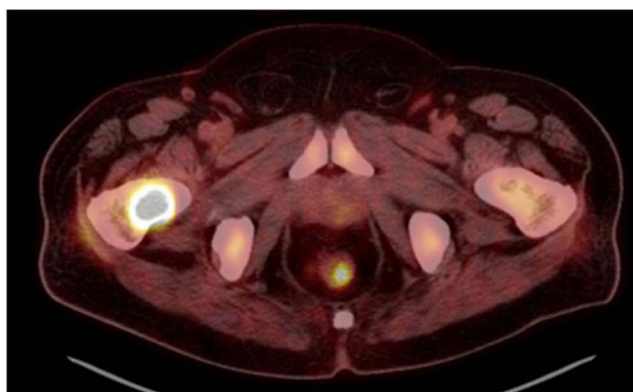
PET-CT scan showing radiotracer uptake of bone metastasis located on right femur. Standard uptake value (SUV) = 22.3.
